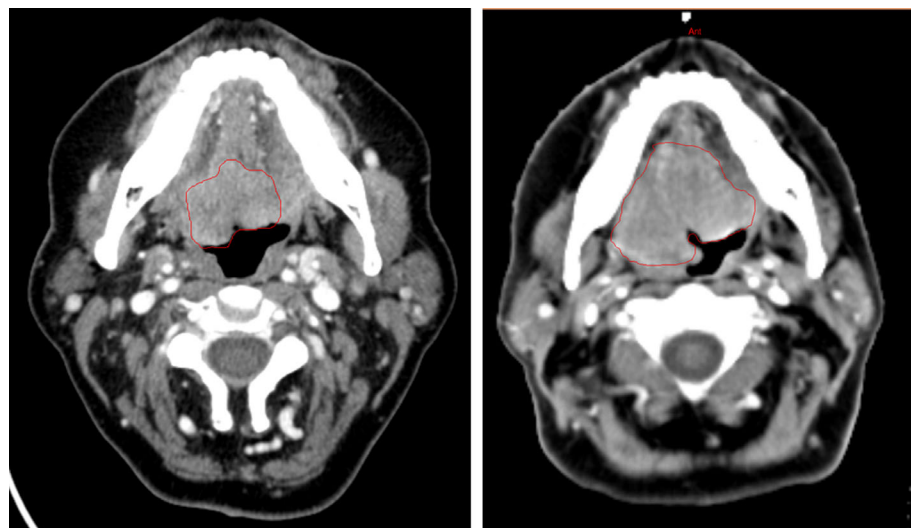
Tumor progression evaluation. Based on volumes calculated on diagnostic CT scan and pretreatment scan, and the delay between these two procedures, tumor volume, tumor volume doubling time, and changes in TNM stage are calculated. In this example, the tumor progressed, within 36 days, with a relative volume increase of 174.7%, giving a tumor doubling time of 20.6 days [Color figure can be viewed at wileyonlinelibrary.com]
